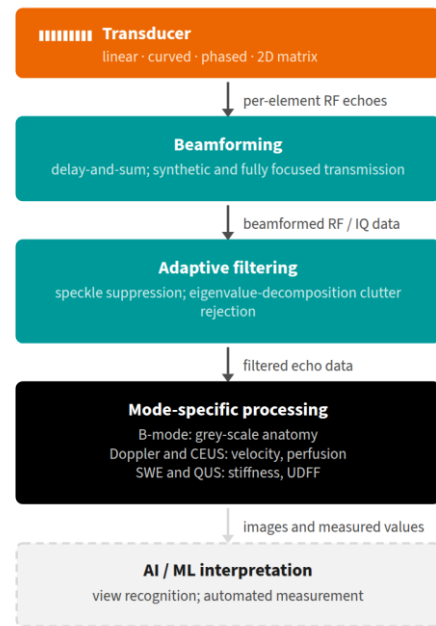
The diagnostic ultrasound signal chain.
